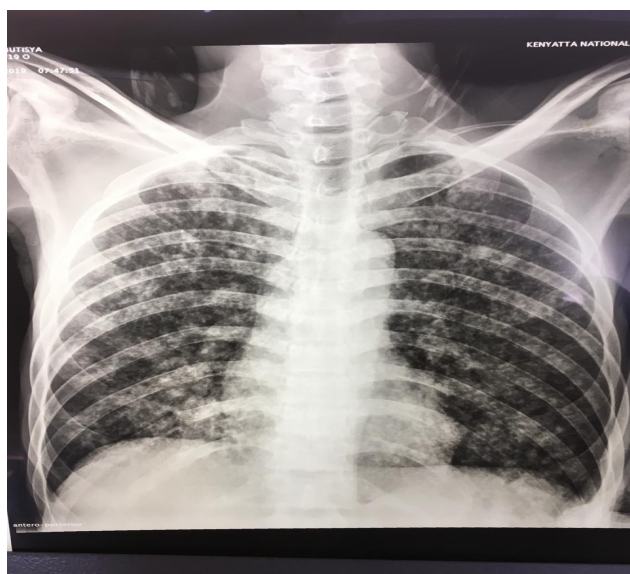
Chest radiograph of the same patient showing a miliary picture (diffuse millet seed sized nodular opacities)
